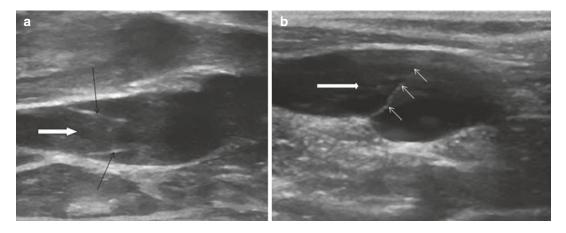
Sonography of the jugular valve: (a) normally structured valve and (b) membranous malformation of the jugular valve severely disturbing the flow
